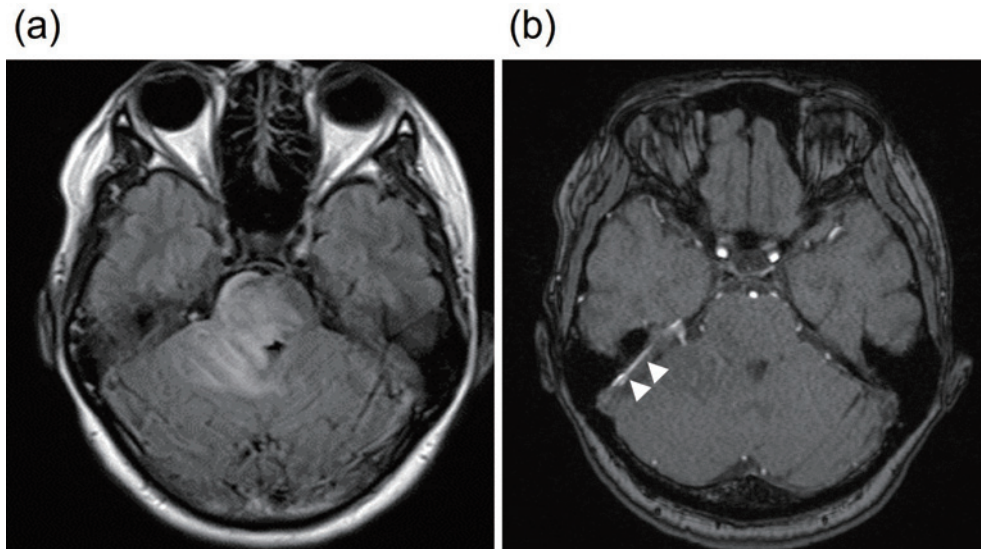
Magnetic resonance images (a) and time-of-flight magnetic resonance image (b) on admission showing venous infarction at the brain stem and cerebellum, including high-intensity signals in the right superior petrosal sinus (arrowhead).
